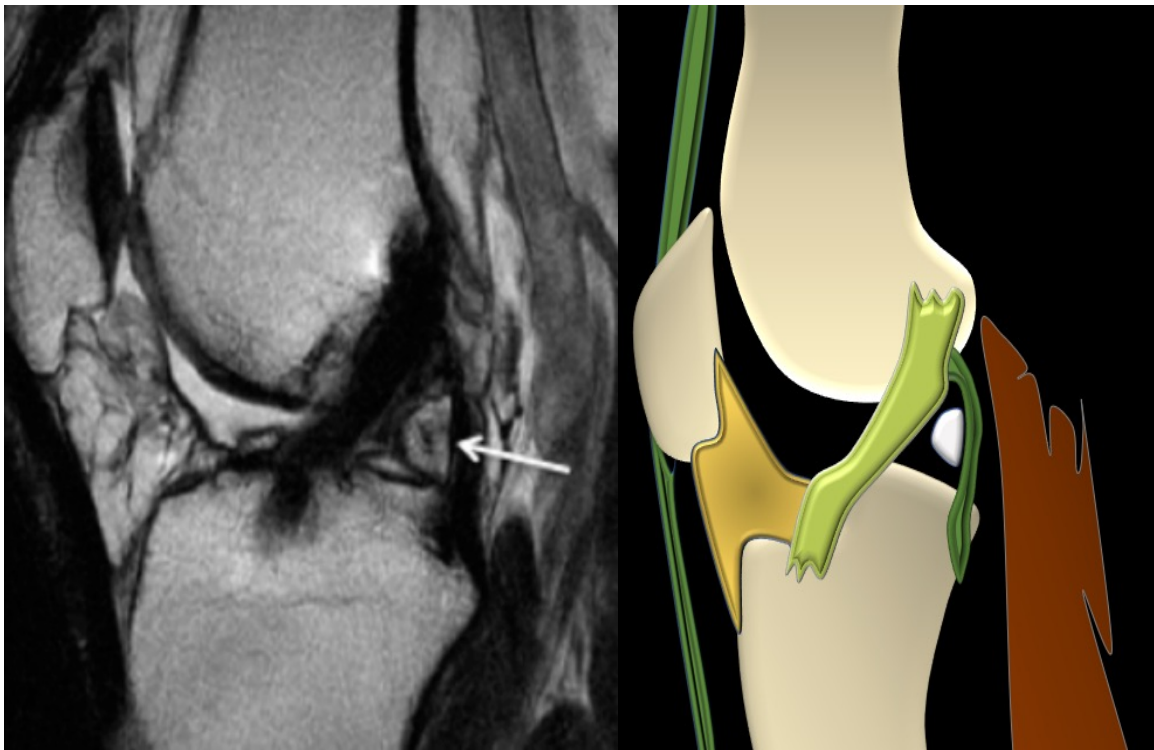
Sagittal T2W MRI showing an intra-articular loose body in a 24-year-old patient following post ACL reconstruction.
